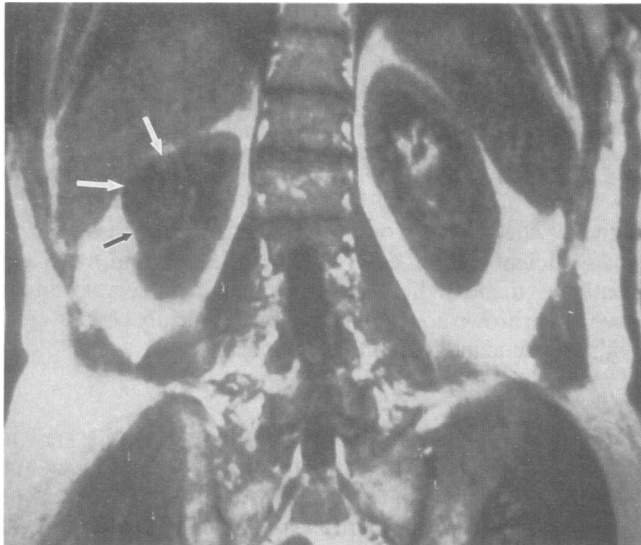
A coronal T1-weighted magnetic resonance image through the right kidney shows a clear plane between the right renal mass lesion (arrows) and the liver.
